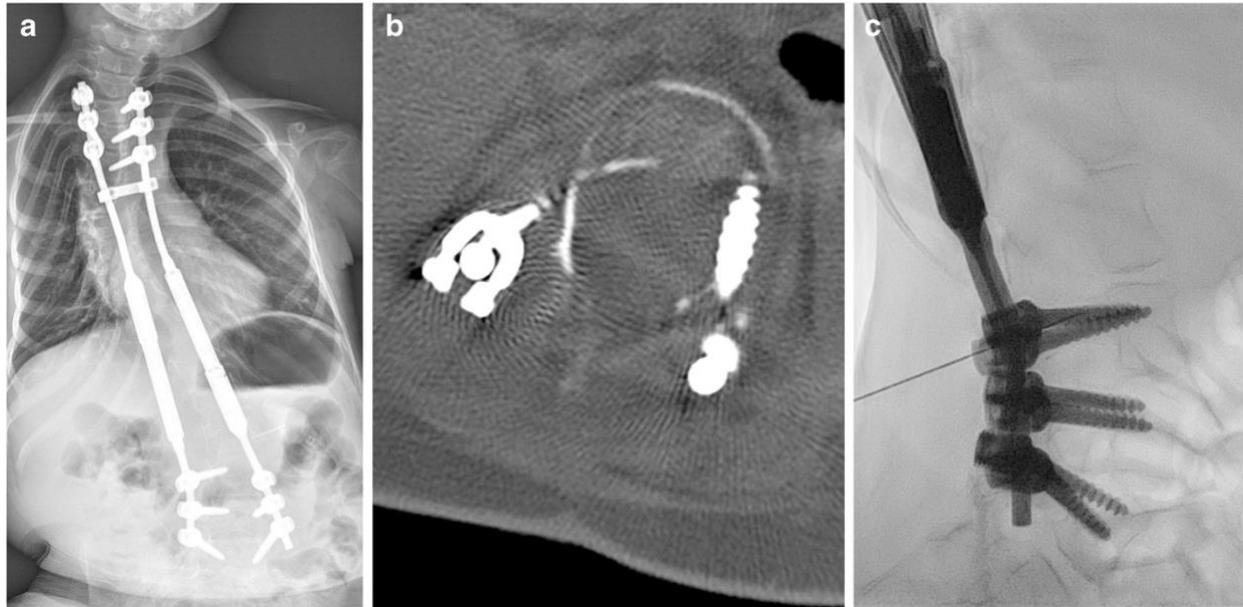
Spinal muscular atrophy type 2 and spinal hardware in a 7-year-old girl. a Anteroposterior radiograph demonstrates scoliosis post repair and neuromuscular disease. b Axial image from pre-procedural non-contrast diagnostic lumbar spine CT demonstrates patency of the posterior spinal canal, with lack of bony fusion, at the level of the most cephalad transpedicular screws. c Lateral fluoroscopic image demonstrates spinal needle tip superimposed over the most cephalad transpedicular screws, positioned in the subarachnoid space at L2-L3 via an interspinous approach. Again, note true lateral projection using vertebral bodies and neural foramina as internal landmarks at the level of interest
